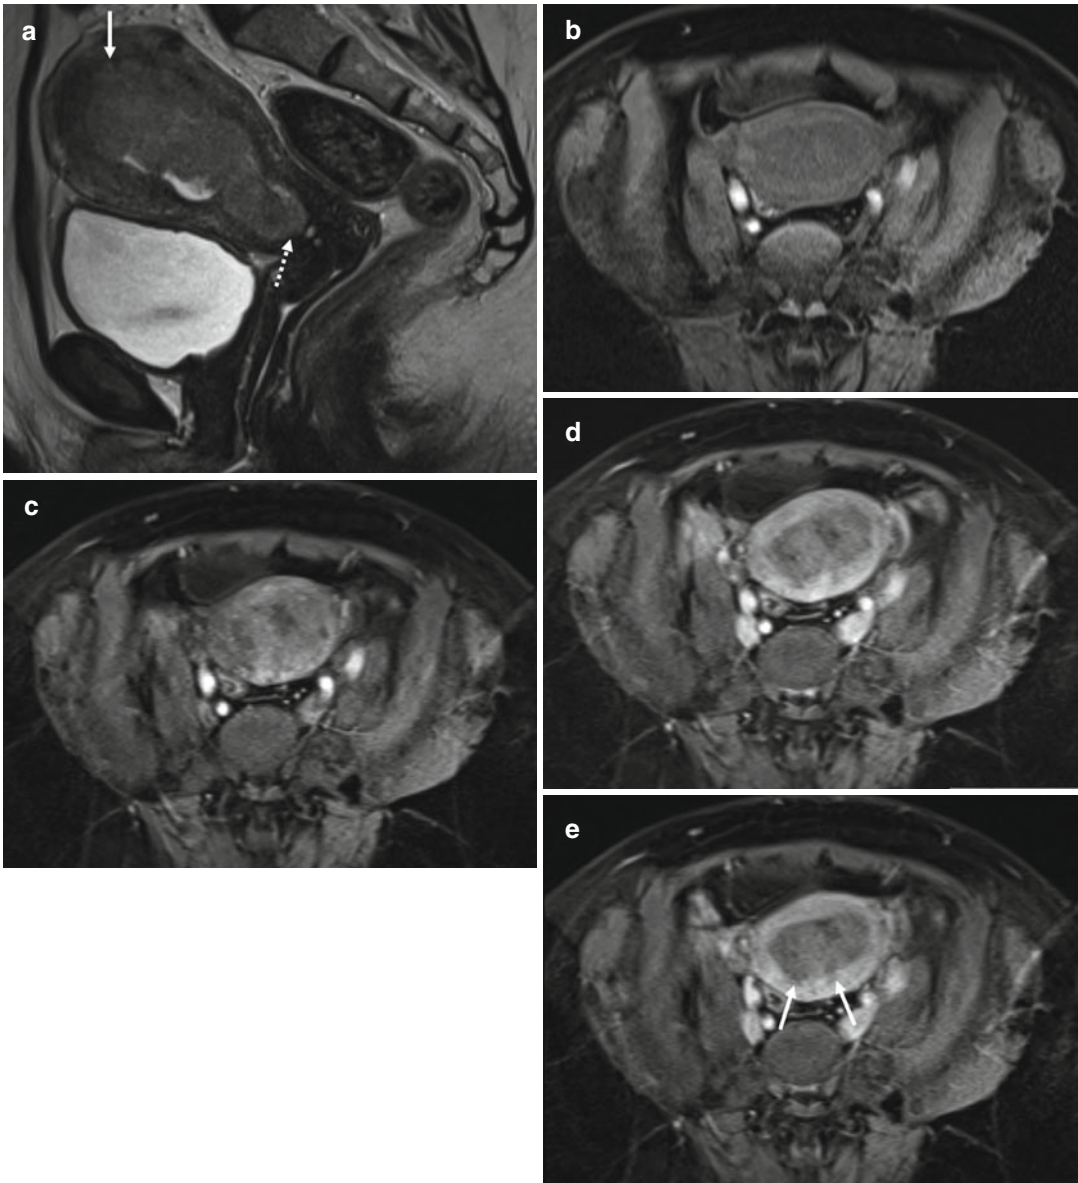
Endometrial cancer in a 58-year-old female: sagittal T2-weighted image (a) demonstrates a large intermediate signal endometrial mass with myometrial invasion superiorly (*arrow*) and cervical stromal involvement at the internal os (*dotted arrow*). The normal myometrium shows progressive enhancement on the axial T1-weighted volumetric interpolated breathhold examination (VIBE)
